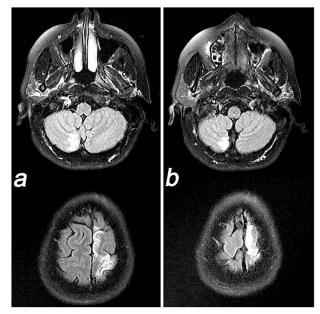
(a and b) Cerebral MRI, axial T2 FLAIR sequences revealed right ischemic cerebellar stroke and left hemispheric stroke. FLAIR: Fluid-attenuated inversion recovery; MRI: Magnetic resonance imaging.
